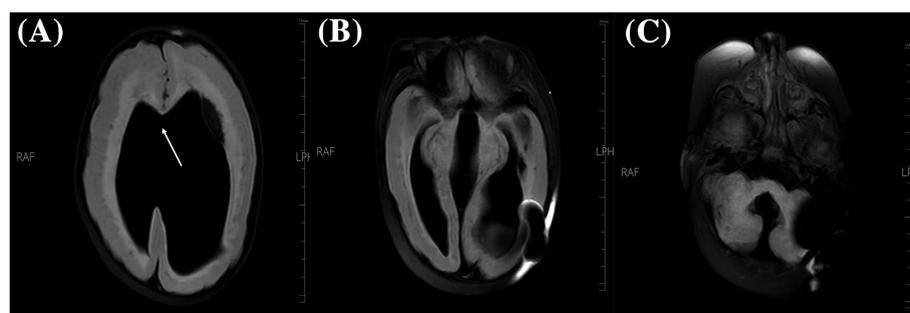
Magnetic resonance imaging of the patient 1 (II 1) at 16 months of age. (A) Dysplastic cerebral cortex; reduced white matter volume; severe hydrocephalus; and callosal agenesis (arrowhead). (B) Massively dilated third ventricle. (C) Massively dilated fourth ventricle
